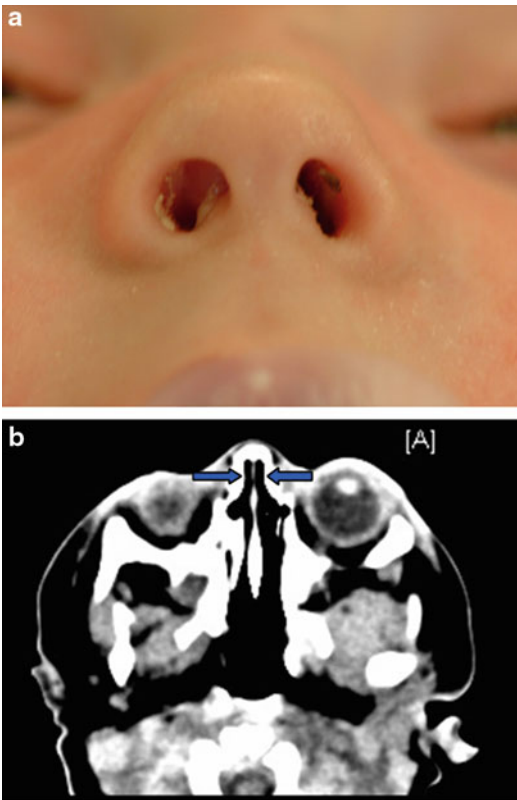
(a, b) A 3-week-old Caucasian boy was seen for respiratory distress and inability to feed. Nasal catheters could not be passed on either nasal side and he was referred for evaluation of possible choanal atresia (a). He struggled with breathing and desaturated every time he ate. Nasal obstruction was persistent. A flexible pediatric (2.4 mm diameter) endoscope was unable to insert beyond the nasal vestibule on either side. Rigid pediatric endoscope (2 mm Hopkins rod) could not be passed through either nasal passage. A non-contrast axial CT scan (b) showed CNPAS with a bilateral combined nasal vestibular aperture width of 5.03 mm (*arrows*) and normal choanae. He underwent bilateral balloon dilation and short-term stenting of the nasal pyriform apertures without the need for additional procedures and remained patent after 12 months at follow-up (Gungor and Reiersen 2014) (Courtesy of Dr. Anil Gungor)
